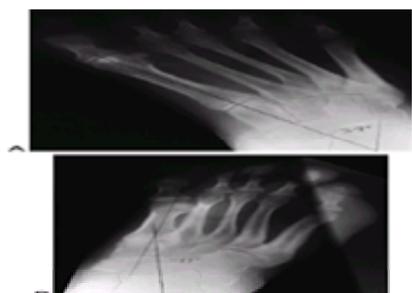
Standing block test radiograph with Plexiglas under the lateral metatarsal heads. The flexibility or rigidity of the subtalar joint can be documented by assessing alignment at the talonavicular joint using the talus–first metatarsal angle. A: Without block. B: With block, the hindfoot varus is corrected.
